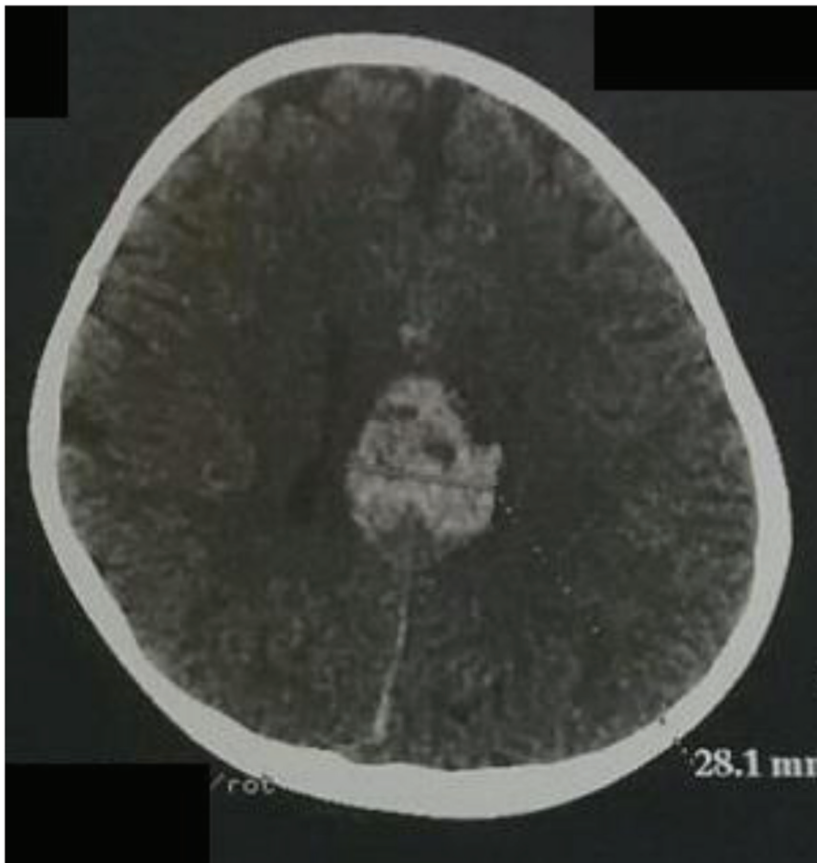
Axial view of brain CT Scan showing the volume of the hemorrhage was decreasing (1,1 cm x 2,6 cm x 2,81 cm in size) on day 4 of conservative treatment
